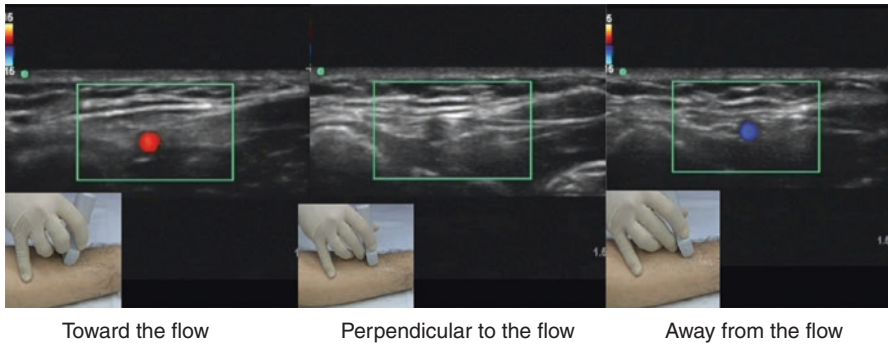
Color Doppler. (Reprinted with permission from Philip Peng Educational Series)
